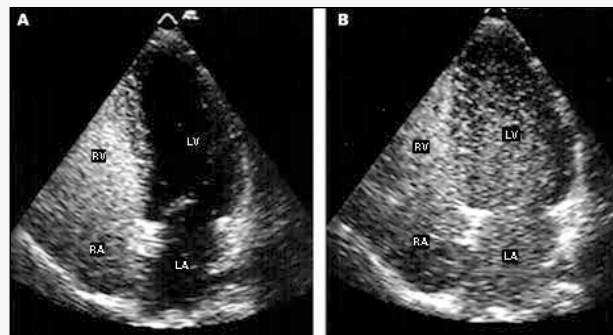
Transthoracic 2-dimensional echocardiogram, apical 4-chamber view: A) presence of contrast in the right chambers; B) presence of contrast in the left chambers after 6 cardiac cycles, compatible with intrapulmonary vascular dilations.
